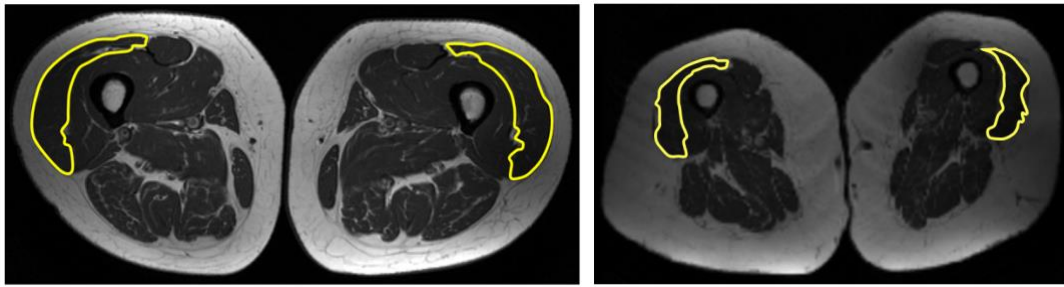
MRI of thighs from two different individuals. ROI, m. vastus lateralis, are highlighted.
